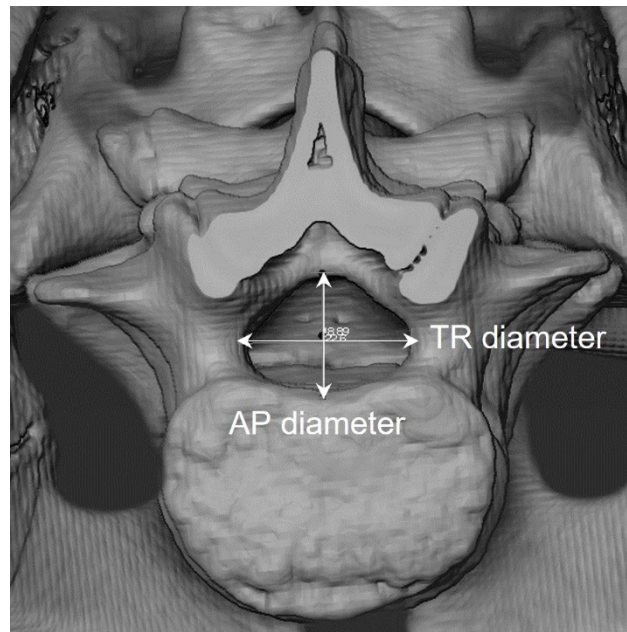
Antero-posterior (AP) and transverse (TR) vertebral neural canal (VNC) diameters taken on virtual surfaces reconstructed from CT scans.
